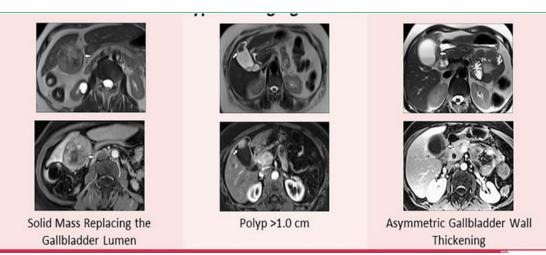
Gallbladder carcinoma and its differential diagnosis at MRI.
